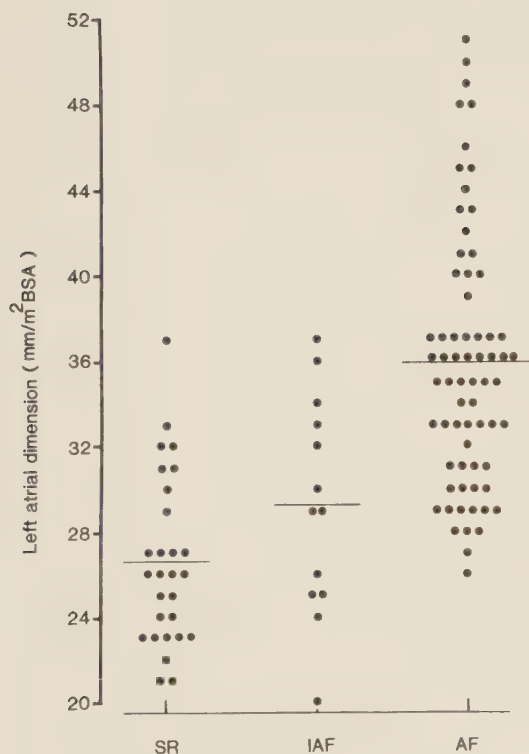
Left atrial dimension (individual patients and mean), as evaluated by echocardiography, related to heart rhythm 10-15 years after commissurotomy (n=109).
